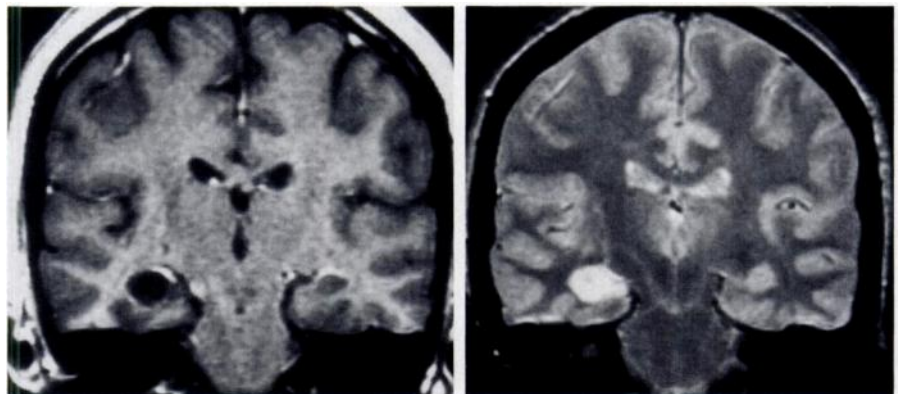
Tumor in a 37-year-old man with poorly controlled complex partial seizures of the right temporal lobe since age 18 years. This lesion was removed and revealed to be a grade 1–2 mixed oligodendroglioma-astrocytoma. The patient has been seizure-free since surgical removal. (a) T1-weighted coronal MR image with contrast material enhancement. (b) First-echo image of a double echo of a long TR sequence. The tumor does not enhance; it is well margined and confined to the hippocampal formation. The imaging characteristics mirror the indolent biologic behavior of the lesion (cf Fig 5a). Tumors enlarge the hippocampus and increase T2 signal intensity. With MTS, however, the hippocampus is atrophic with increased T2 signal intensity.
